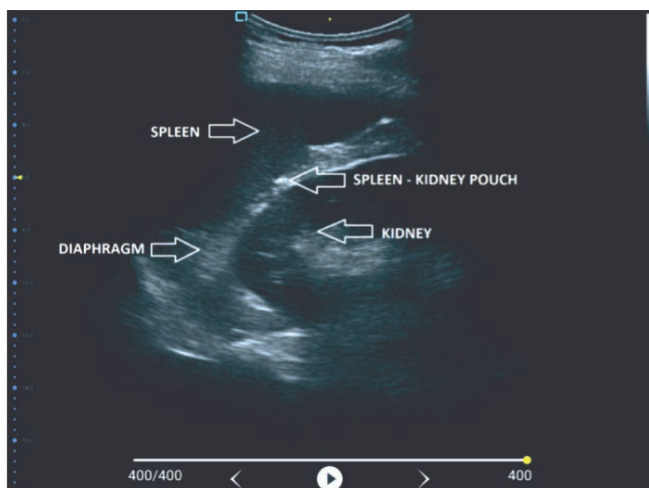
Ultrasound image from projection Left Upper Quadrant
